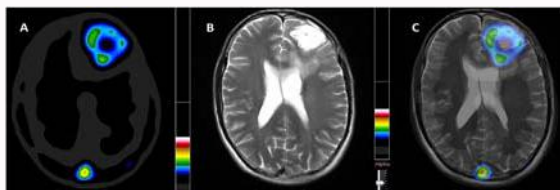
An increased ^{99m}Tc -MDM uptake SPECT (A), contrast enhancement on CE-MR and fused SPECT/MR images (B & C) indicating metabolically active GBM disease pre-operatively in a 39 years old male. ^{99m}Tc -methionine uptake (A) demonstrates metabolically active tumor in the rim with central necrotic mass. CE-MRI (B) indicates homogenous contrast enhancement in the entire tumor bed.
